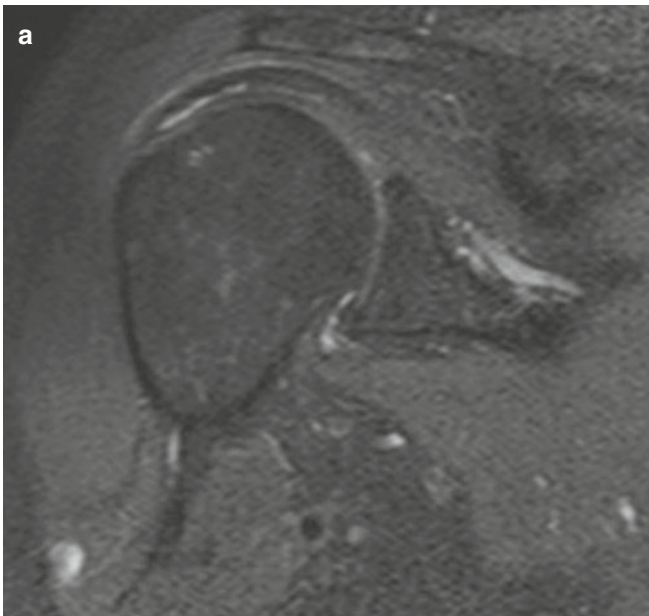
Intralaminar lesion of the supraspinatus tendon. (a) MRI (coronal STIR) image; (b) pseudo-cyst in the myotendinous junction secondary to the intralaminar lesion of the supraspinatus tendon
